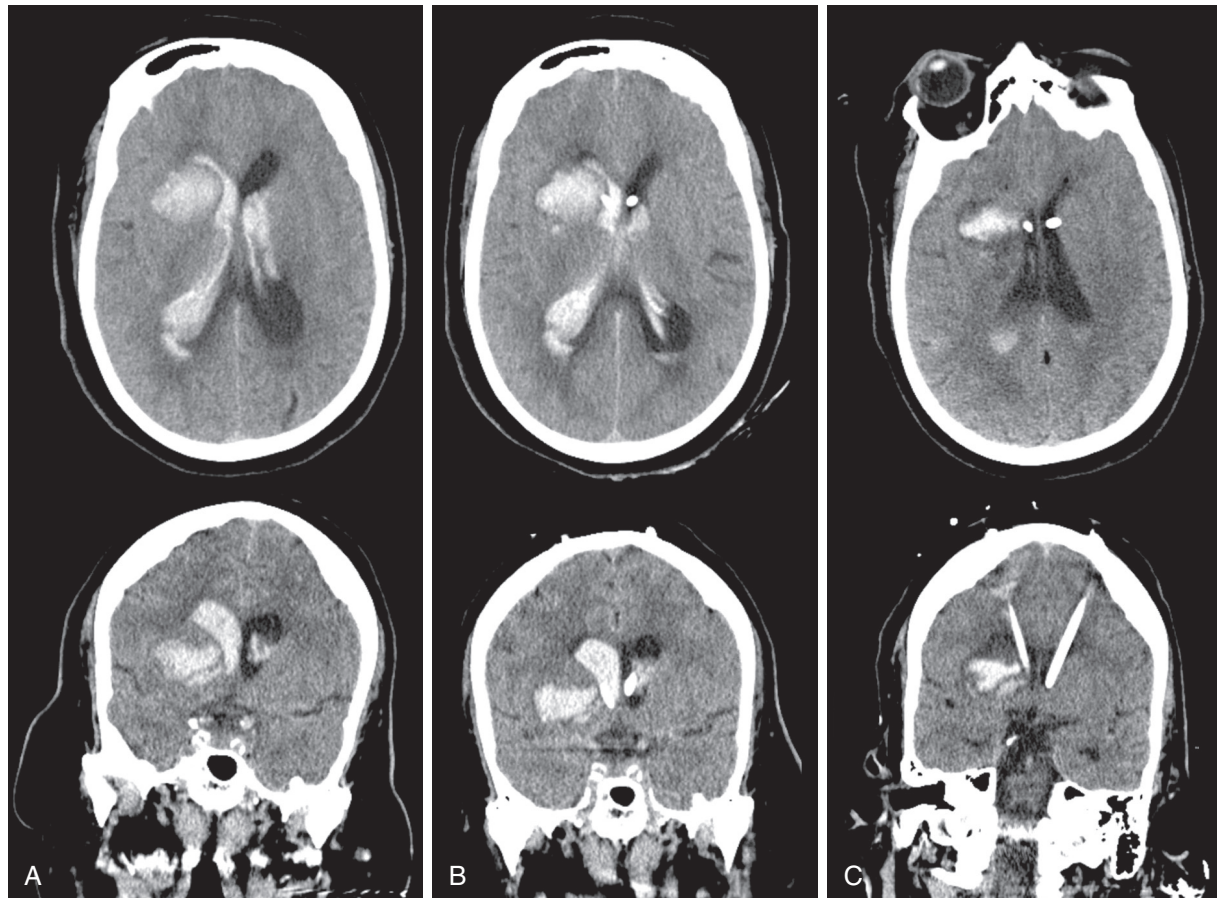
CLEAR intervention for intraventricular hemorrhage, axial (top) and coronal (bottom) non-contrast-enhanced CT scans. (A) Images in 69-year-old woman with a hypertensive right intracerebral hemorrhage with extension into the ventricular system resulting in casting of the right lateral ventricle as well as the third and fourth ventricles. The patient was increasingly somnolent. (B) Emergency placement of an external ventricular drain into the less casted ventricle to control intracranial pressure was completed, along with a second catheter placed into the right lateral ventricle, directly into the ventricular clot with all catheter perforation in contact with clot. (C) Three doses of recombinant tissue plasminogen activator were injected into the right lateral ventricle (every 8 hours, 1 mg/mL), resulting in resolution of ventricular clotted blood as well as clearance of the third and fourth ventricles. The patient did not require a shunt and achieved a modified Rankin Scale score of 2 after 3 months.
